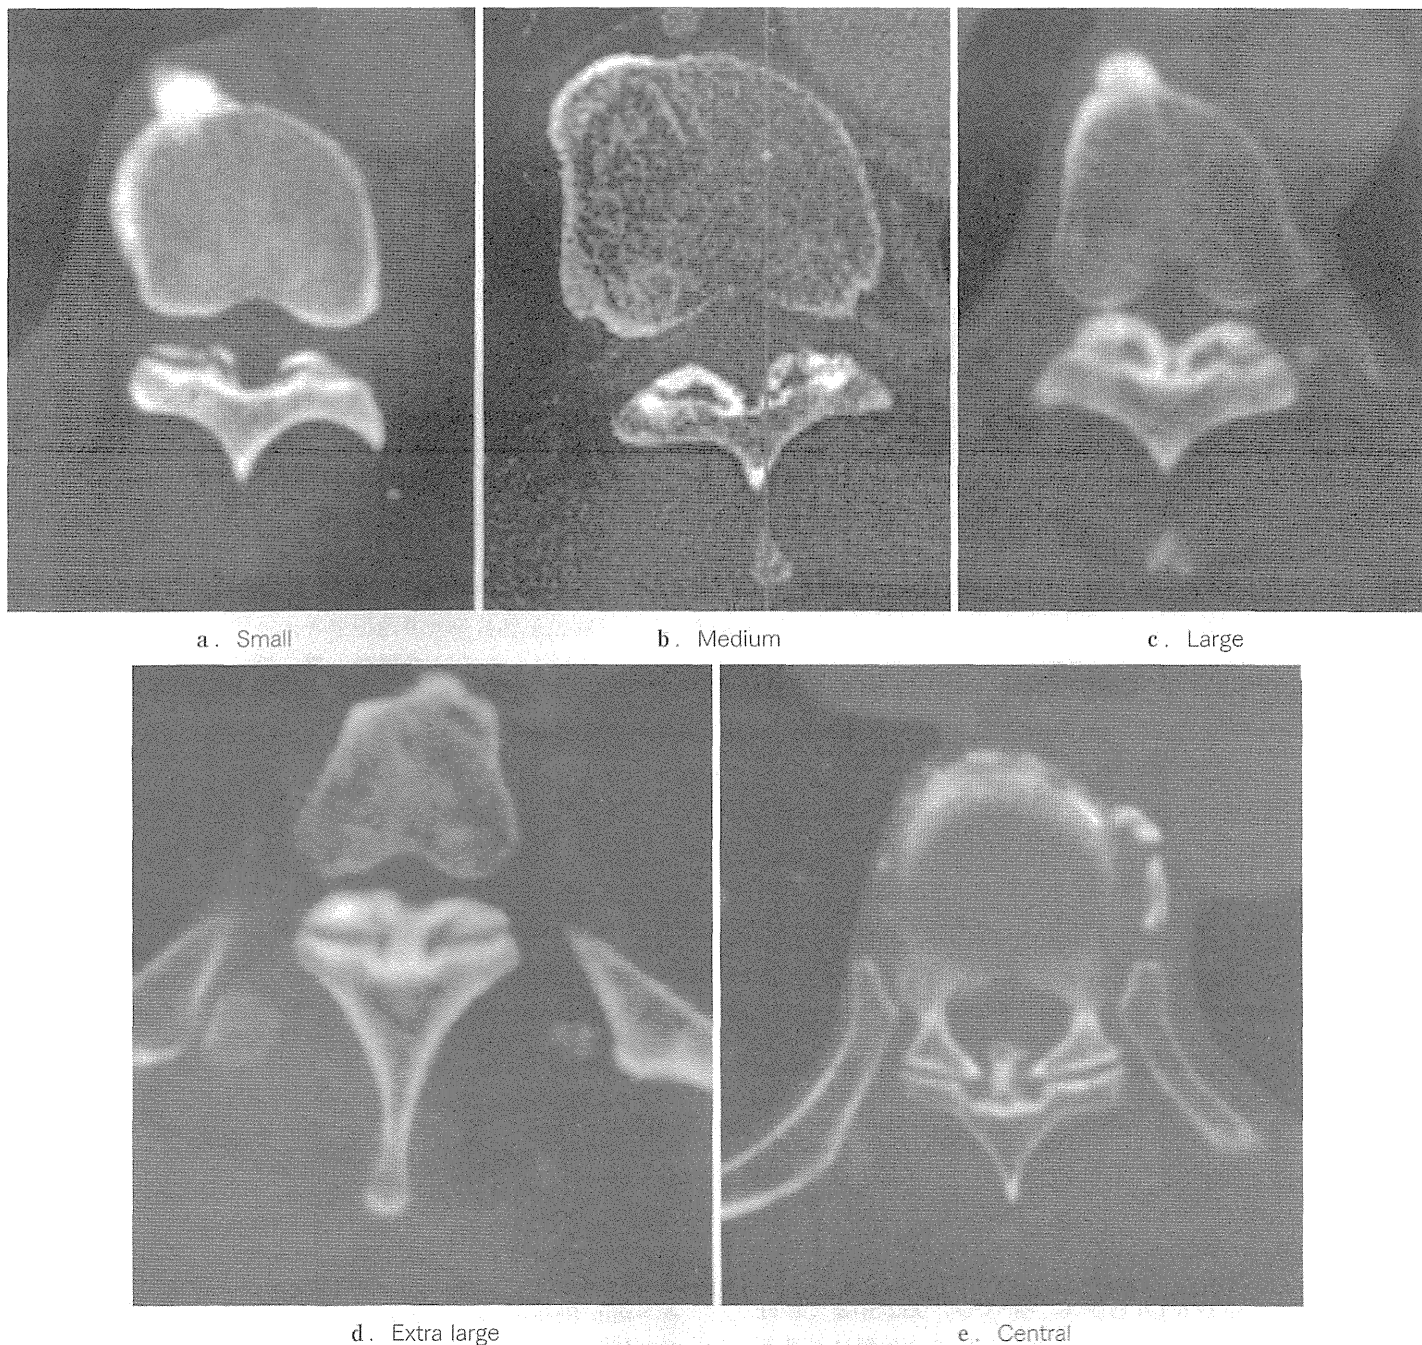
CT 水平断における胸椎黄色靭帯骨化症の分類 (文献1より転載)
